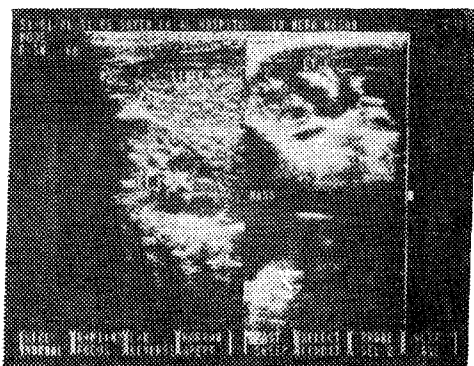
a) Nephrosonography showed : Bilateral hydronephrosis.
